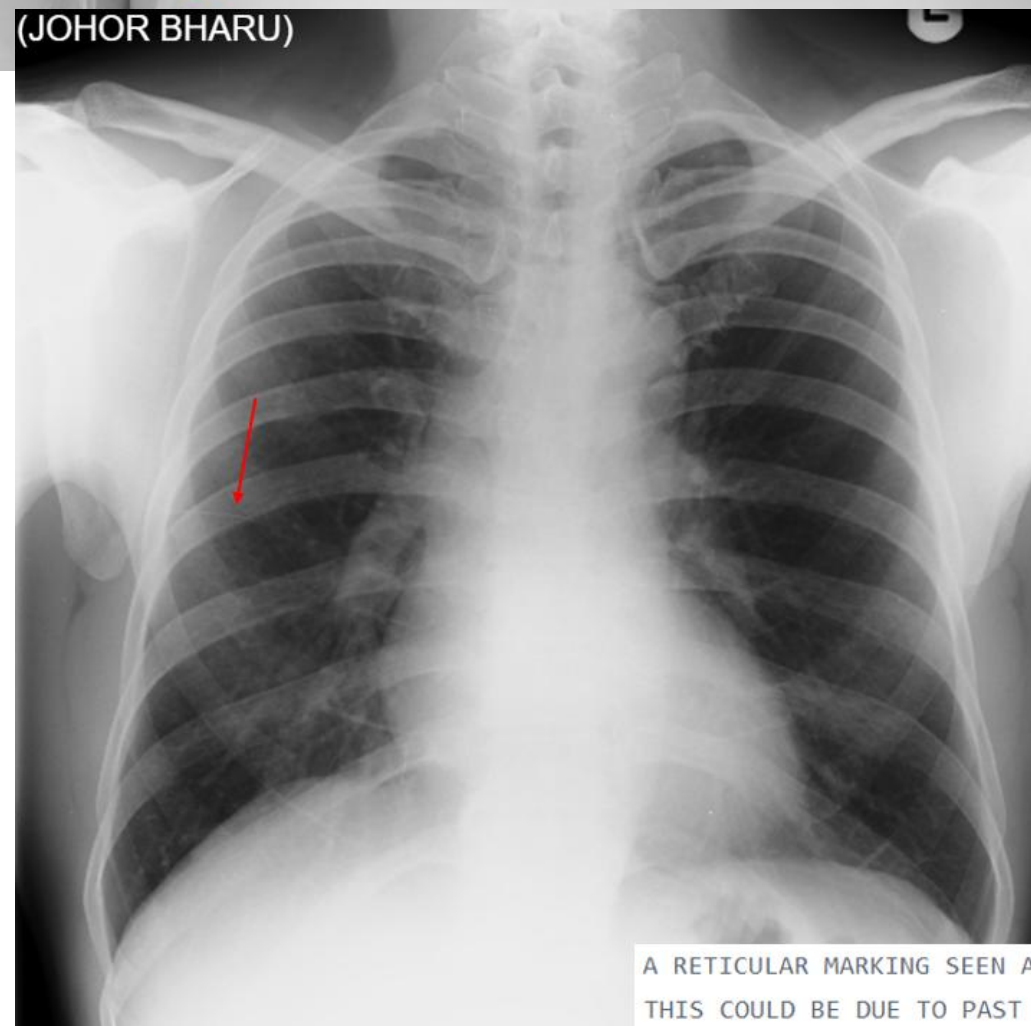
Image A was reported as fibrosis RMZ - UNSUITABLE. X-ray was repeated B and is normal. The band seen in A is plate atelectasis and is due to poor inspiration. B is a much better full inspiratory image and the atelectasis is not seen anymore.
